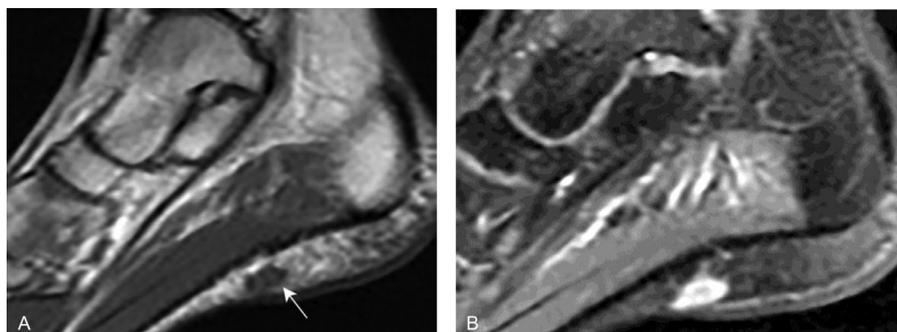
Epithelioid sarcoma. (A) Sagittal T1WI shows a small superficial mass with ill-defined margins (white arrow). (B) Sagittal postcontrast fat saturated T1WI shows intense contrast enhancement of the mass. T1WI, T1-weighted images.
